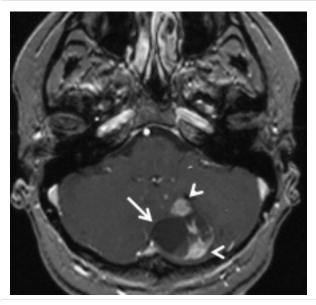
Enhanced T1 magnetic resonance image showing a heterogeneous cystic masse (arrow) in the left cerebellum with an enhanced solid nodule in its anterior and posterior parts (head arrows).
